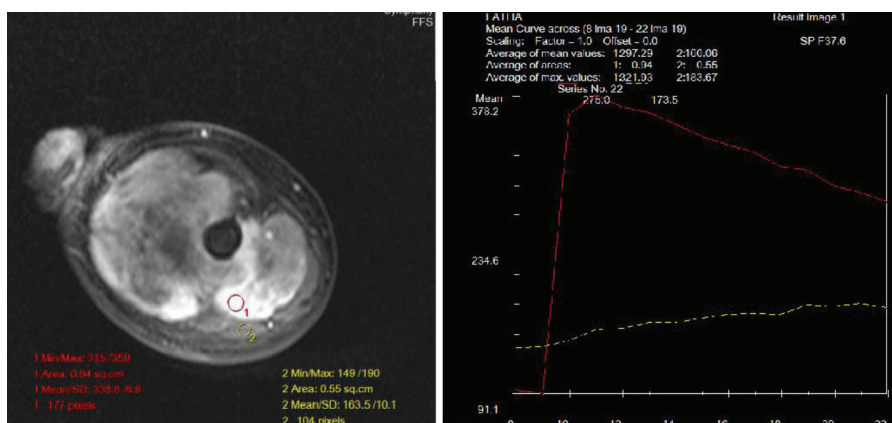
Dynamic contrast enhanced MRI with TIC analysis shows heterogeneous enhancement. The time intensity curve shows rapid initial enhancement and delayed washout. Type 4 curve. HPE: Malignant pleomorphic sarcoma.
